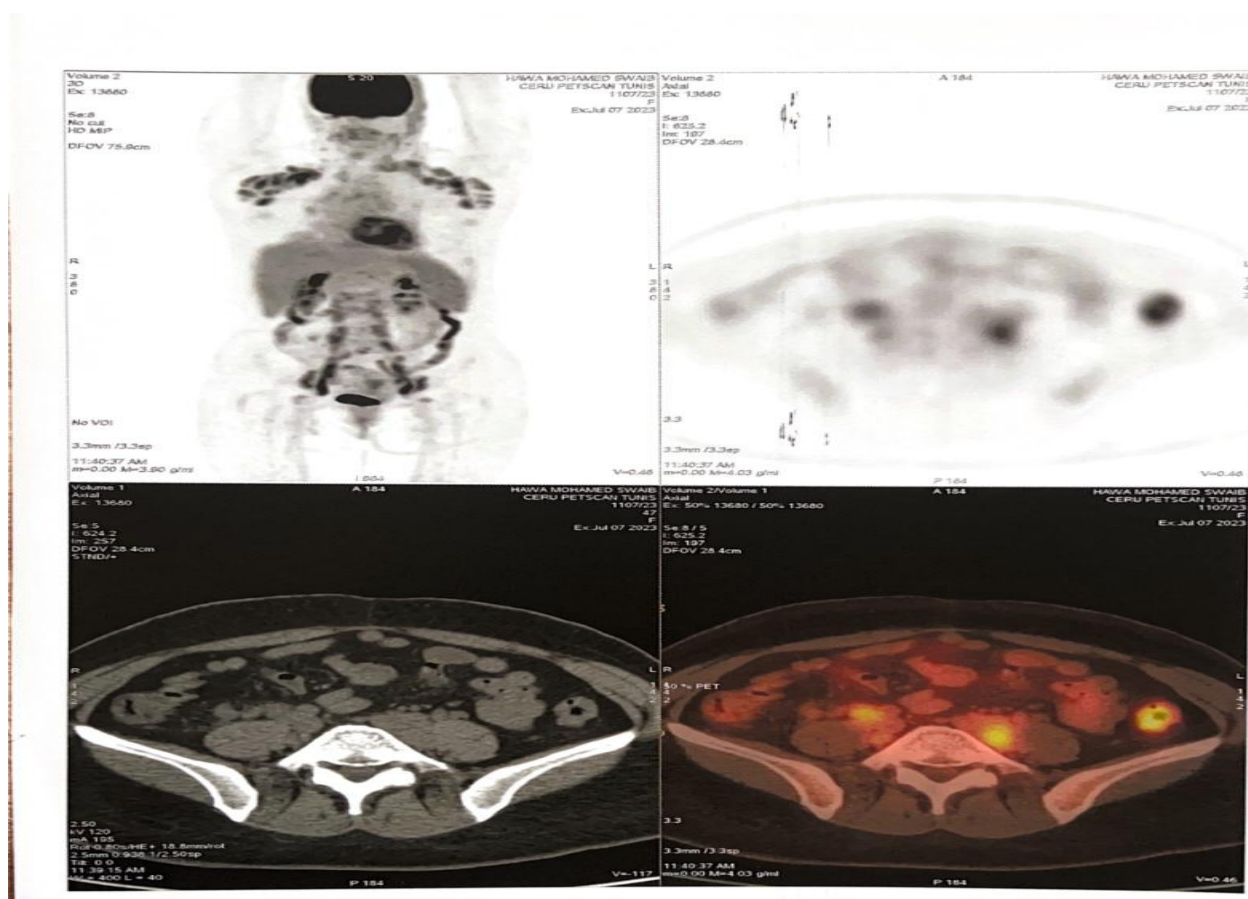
Detailed axial PET-CT sections showing hypermetabolic activity in the retroperitoneal lymph nodes.
